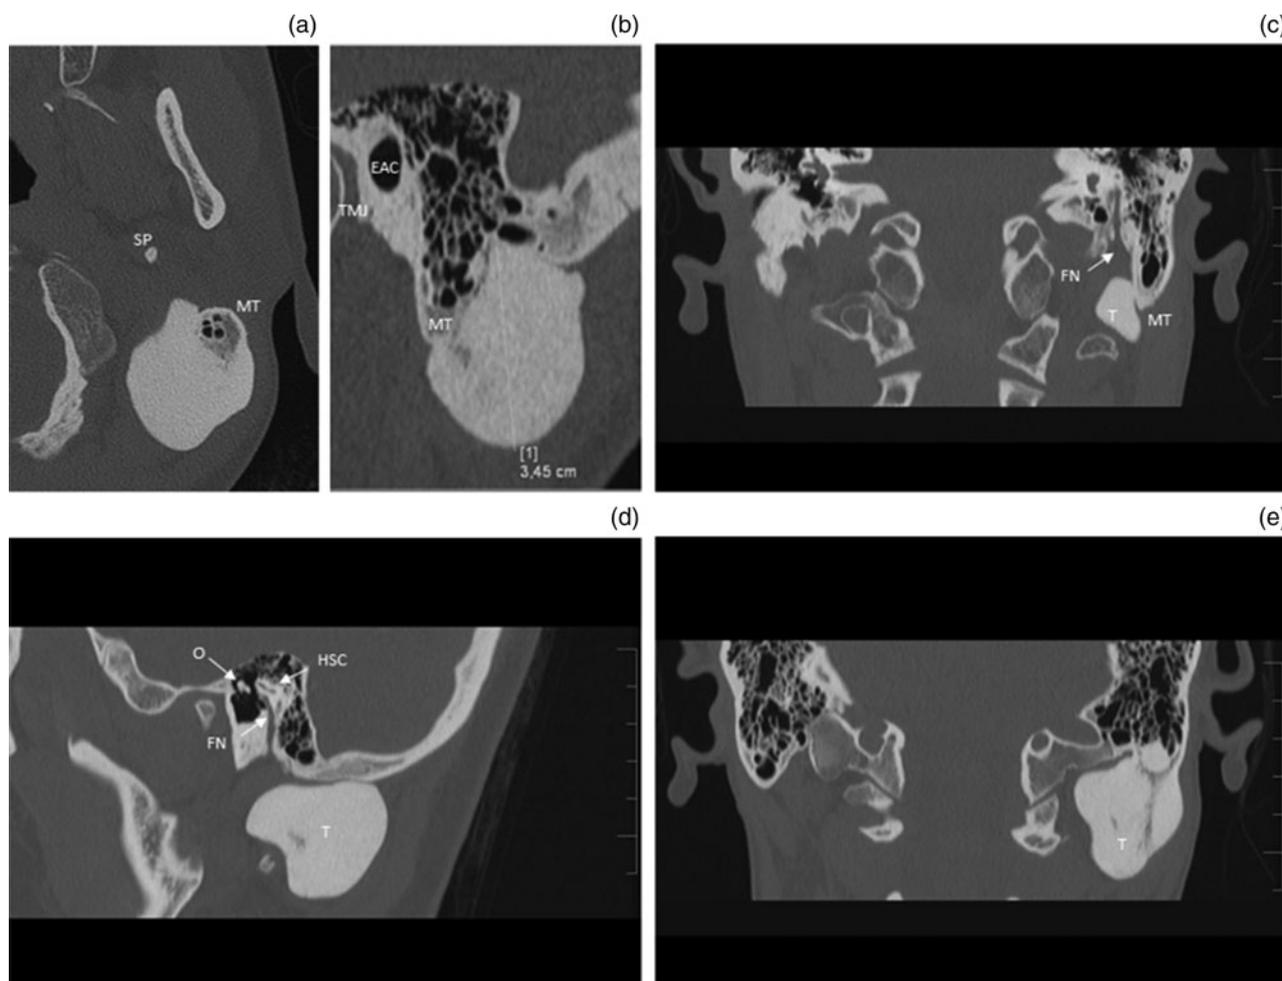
Pre-operative computed tomography scan images: (a) axial view showing left mastoid process tumour (taken from the Appendix 1 video); (b) sagittal section of 3.45 cm mastoid tumour; (c) coronal view at the level of the facial nerve; (d) sagittal section, middle ear; and (e) posterior coronal section. SP = styloid process; MT = mastoid tip; EAC = external auditory canal; TMJ = temporomandibular joint; FN = facial nerve; T = tumour; O = ossicles; HSC = horizontal semicircular canal
